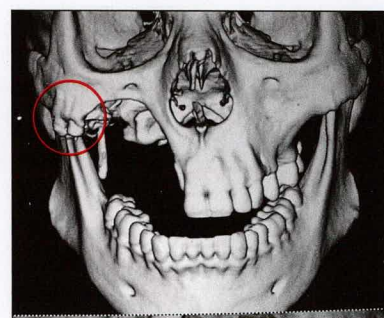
Three-dimensional CT scan showing the zygomatic implants in a coronal view.
